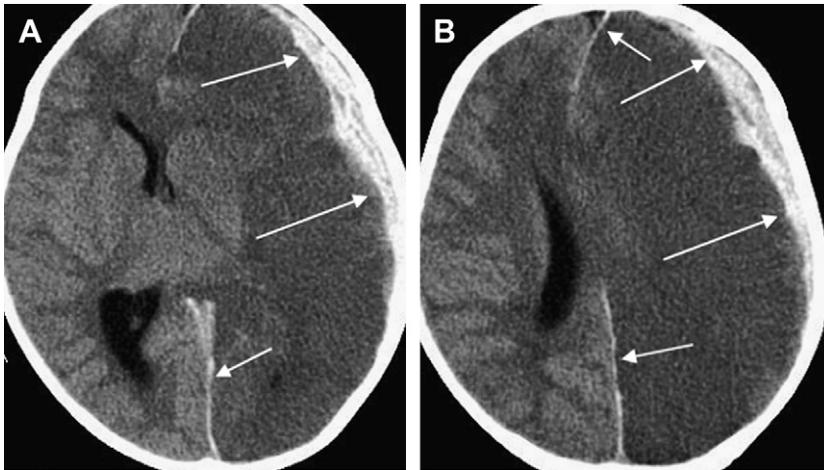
Twenty-month-old infant with triad and alleged NAI. Left SDH with cerebral cortical and pial AVM at autopsy. CT (A, B) shows left mixed-density SDH and SAH (long arrows) plus interhemispheric hemorrhage (short arrows) with marked left cerebral swelling and shift.
